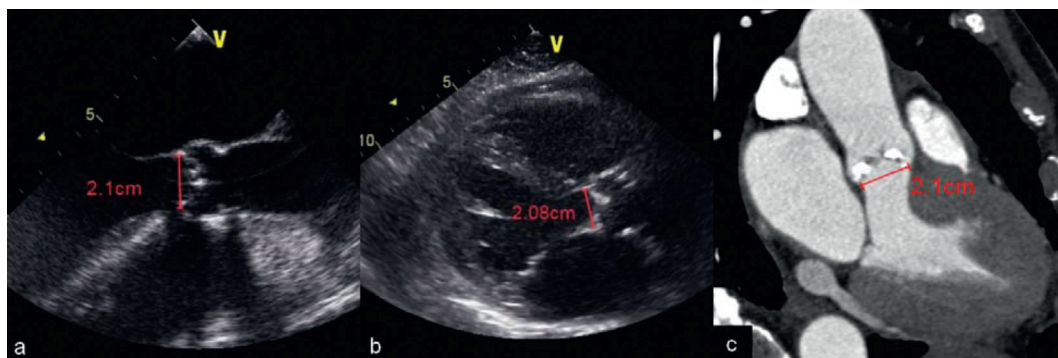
Measurement of the aortic valve annulus with different modalities. Measurements of the aortic valve annulus in (a) TEE, (b) TTE and (c) CT imaging (in an “echo-like” 3-chamber view).
